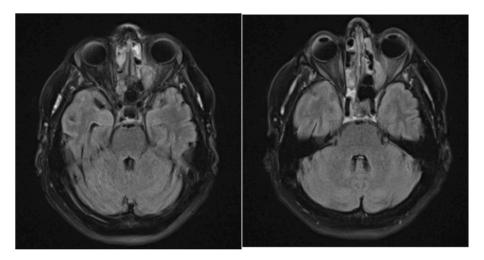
A/2B: MRI Brain: Left orbital extraconal lesion measuring up to 20 mm with avid enhancement on postcontrast imaging. No definite local invasion or perineural tumor spread.
